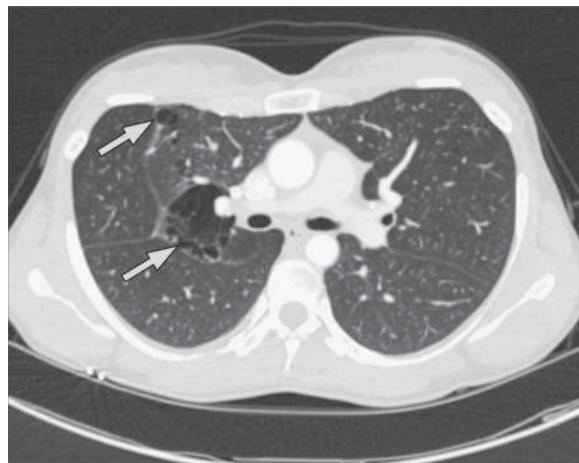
High-resolution CT thorax showing multiple basal cysts. (From Hopkins TG, Maher ER, Reid E, et al. Recurrent pneumothorax. *Lancet*. 2011;377:1624. Fig. 1.)
